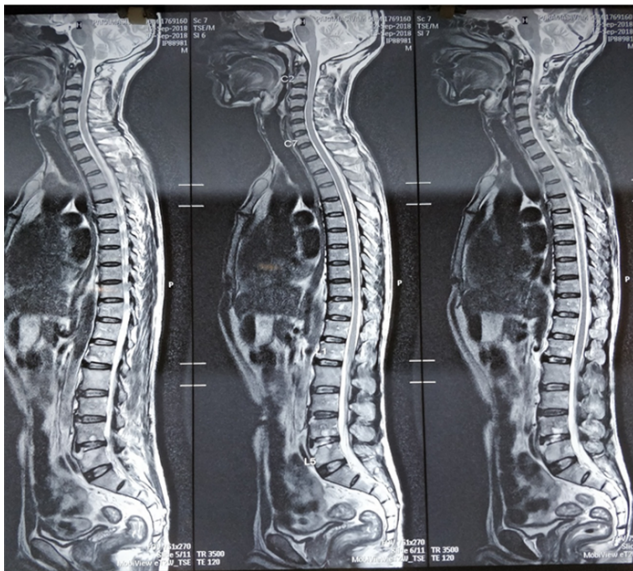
MRI of the spine showed a cortical break in the L4-L5 region with pre-vertebral collection
